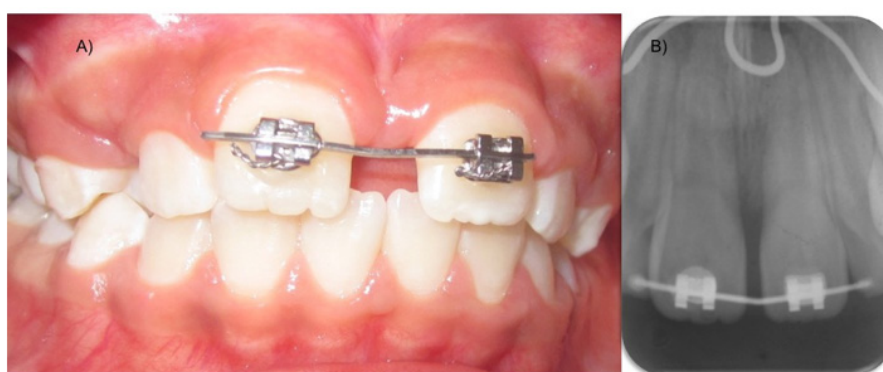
Modification of the orthodontic mechanics and anchorage reinforcement. (A) Intraoral photograph showing the modified orthodontic mechanics following alteration of the long axis of the maxillary central incisors. (B) Periapical radiograph showing the brackets bonded to the maxillary central incisors and the transpalatal arch used to reinforce posterior anchorage and prevent unwanted space loss during orthodontic correction.
